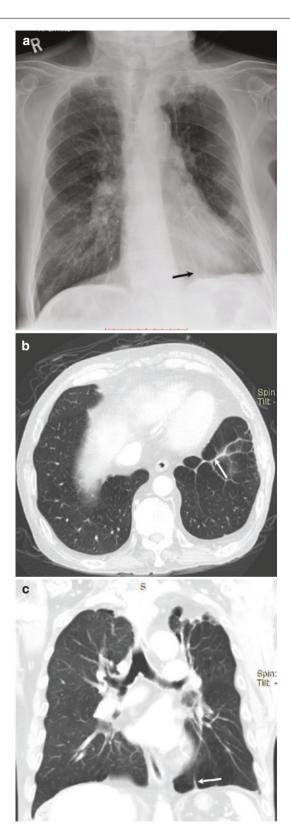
Juxtaphrenic peak sign or "Katten sign" in a patient with upper lobe fibrosis. (a) Frontal chest radiograph shows scarring and volume loss in left upper lobe with tenting of the diaphragm. (b) Axial CT image from the lung base shows an inferior accessory fissure (arrow). (c) Coronal CT image shows volume loss in left upper lobe with stretching of the inferior accessory fissure (arrow)
